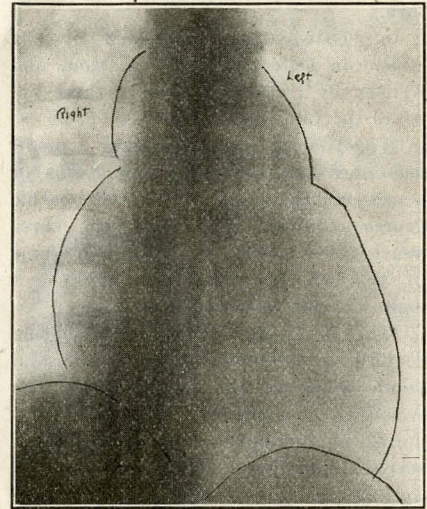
Heart dilatation with mitral and tricuspid regurgitation. Clinically and Radiographically a normal heart after two months Osteopathic care. Primary Osteopathic lesion at second dorsal. Plate taken at a distance of 60 inches from tube target.
